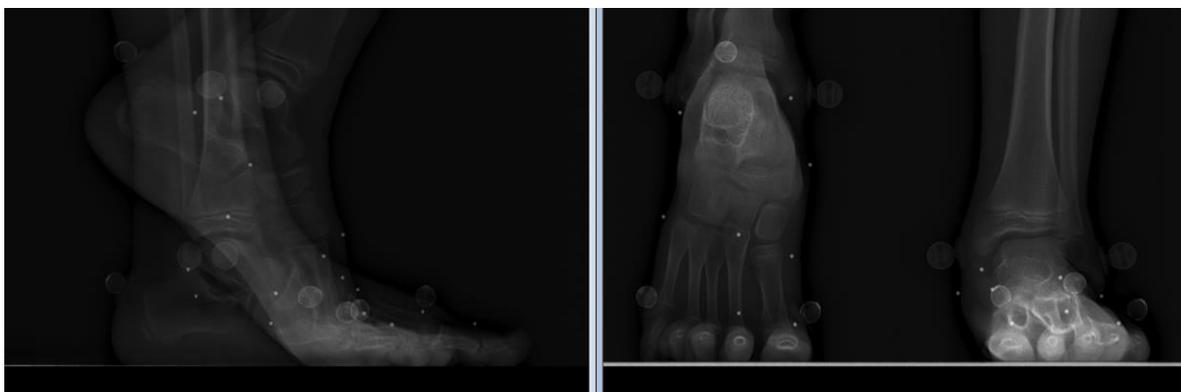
lateral and anteroposterior view of the biplanar X-ray acquisition with the markers already positioned.
